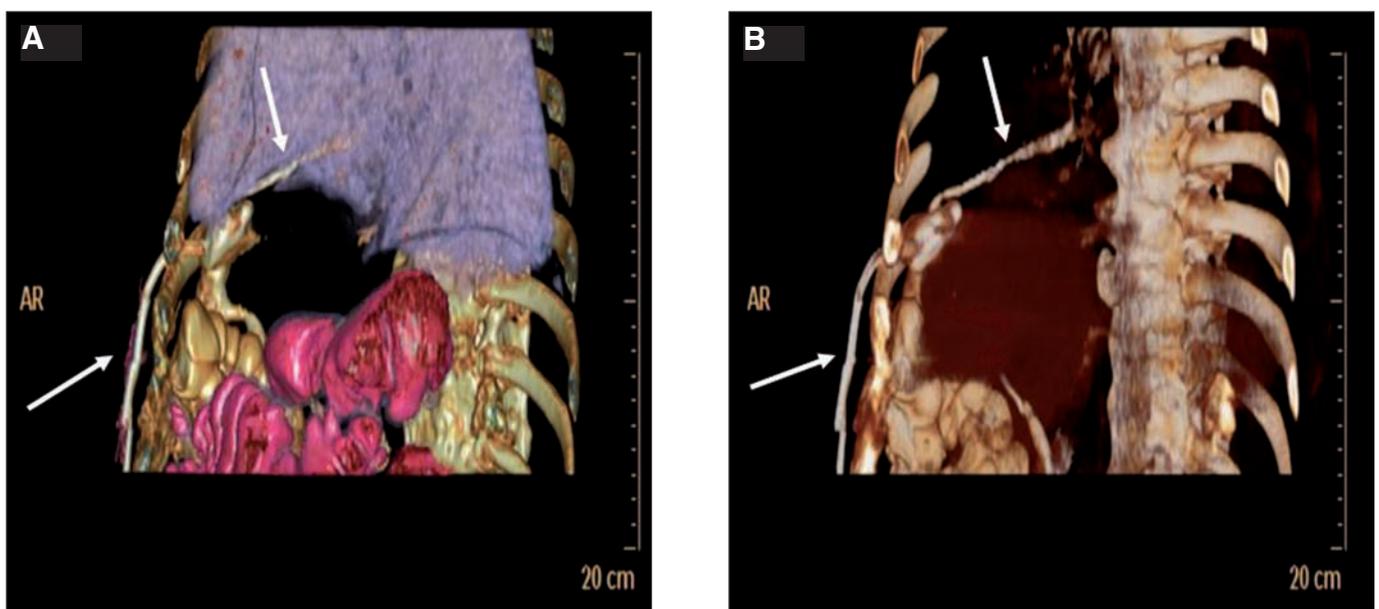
A and B. CT scan 3-D reconstruction showing a percutaneous biliary drainage (lower arrows) which leads to identify a fistulous bronchobiliary pathway after contrast administration (upper arrows).
